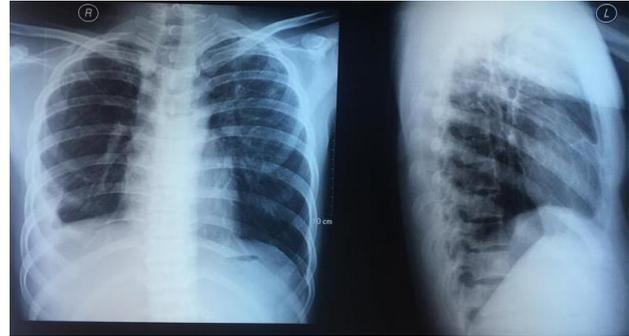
Chest X-ray revealed the fibro infiltrates process in both hemithoraxes, homogenous opacity at the right lower hemithorax, and the costophrenic angle blunting at the right hemithorax
